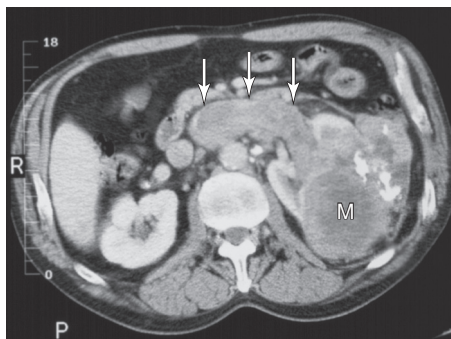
Renal cell carcinoma. A computed tomography (CT) scan at the mid portion of the kidneys demonstrates M, a large left renal mass that extends into the renal vein and into the inferior vena cava (arrows). (From Mettler F. *Essentials of radiology*. 2nd ed. Philadelphia: Saunders, 2004, Fig. 7-25.)
